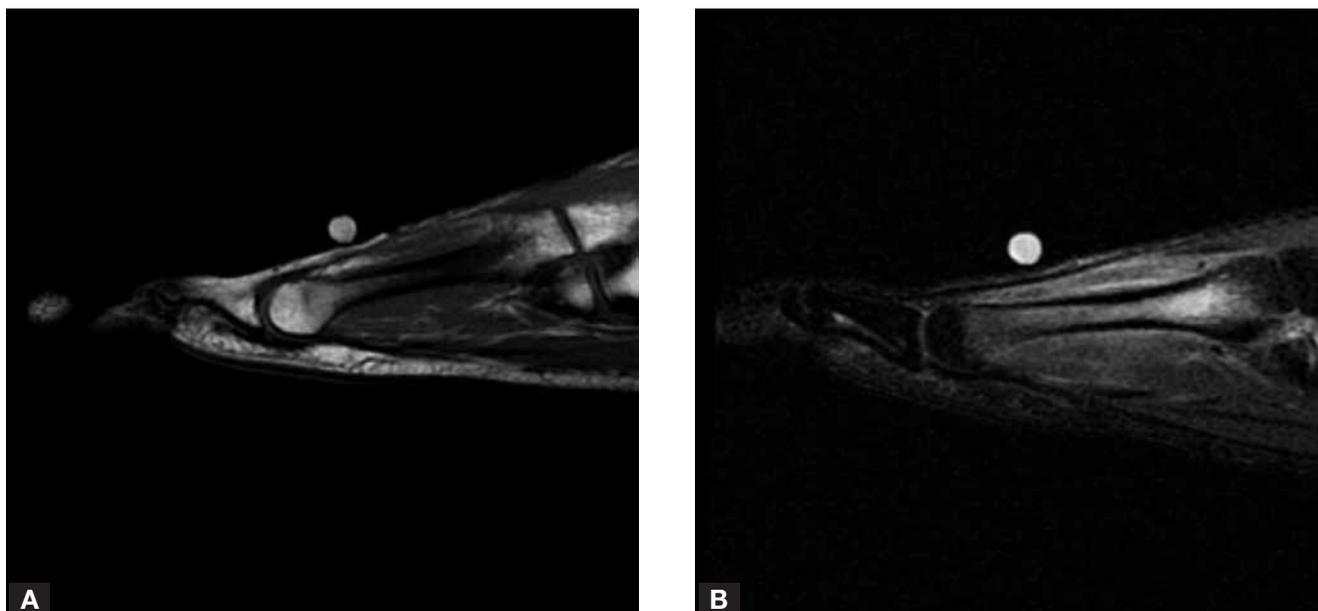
Metatarsal stress reaction. Sagittal T₁-weighted (A) and sagittal short TI recovery (B) forefoot sequences show bone marrow and soft-tissue edema secondary to stress reaction of the metatarsal shaft. Radiographs (not shown) were negative.
